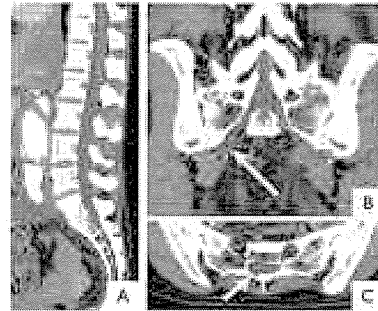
CT images of 46-year-old female with Loey-Dietz syndrome. Sagittal image of the normal dura (A). Coronal image of right lateral meningocele (arrow) (B). Axial image at S1 shows asymmetric dilatation of the dura (arrow) (C). In this case, visual inspection could detect dural ectasia, but quantitative evaluation could not.
